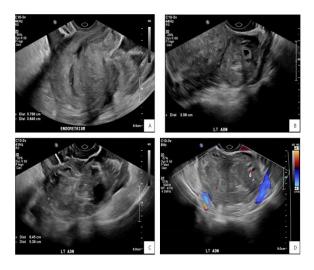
Ultrasound images; (A) empty uterus and small amounts of hemoperitoneum in the pouch of Douglas; (B) and (C) left adnexal mass; (D) vascularity supplying adnexal mass.
